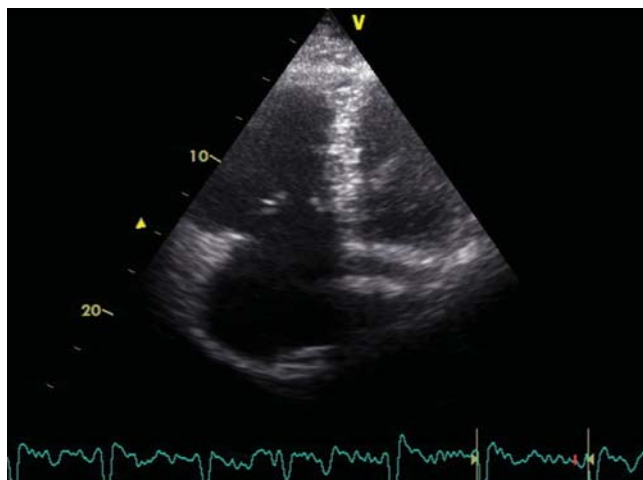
Transthoracic echocardiographic B-mode image in apical view showing moderately dilated right ventricle.
